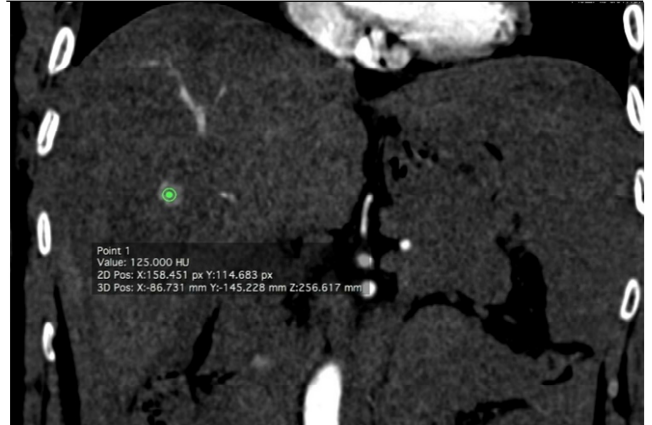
Coronal reformatted CT section showing active contrast extravasation in liver parenchyma (arrow head) in Arterial phase.
